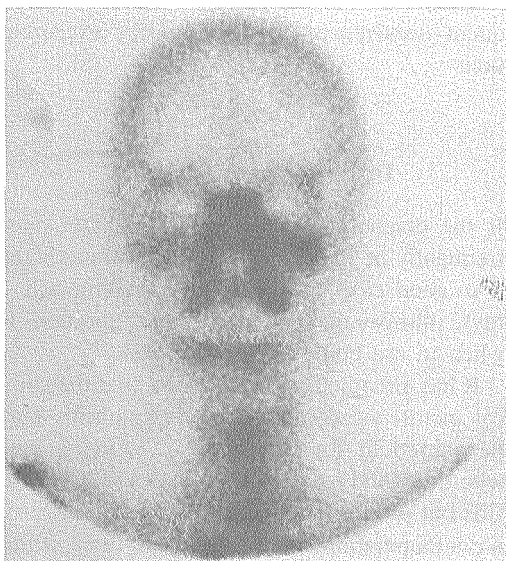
Cranium scintigram shows a very intensive and inhomogeneous accumulation of radioactive indicator in the left maxilla projection. The finding points to a dynamic remodelling in the region.
